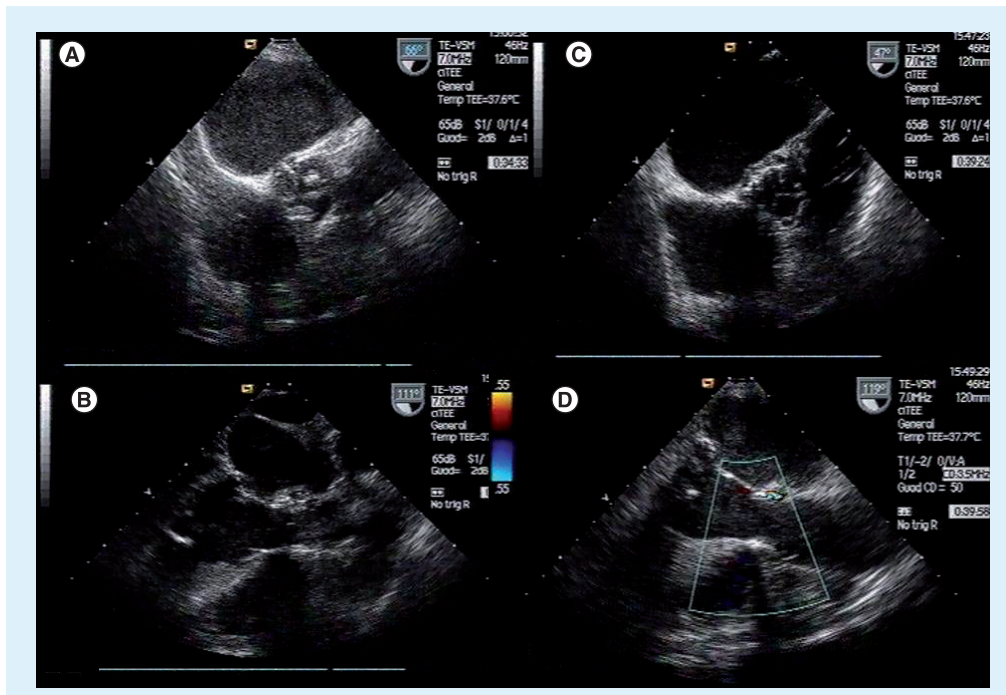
Transesophageal echocardiographic aortic valve prosthesis deployment.
